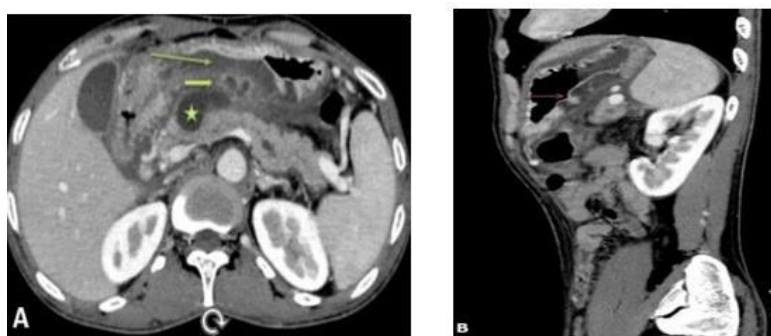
Contrast-enhanced CT images (A – axial, B – sagittal) demonstrating a walled-off necrotic collection in the pancreatic bed (star) with focal discontinuity of the posterior gastric wall and enhancing fistulous tracts communicating with the stomach (arrows), consistent with pancreatico-gastric fistula.
